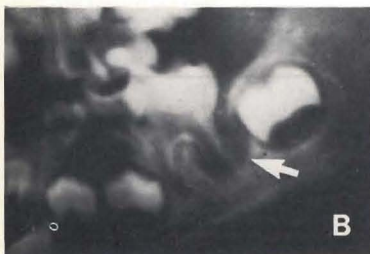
Panoramic radiograph showing lucency in the area of the distal part of the mandibular first molar.
